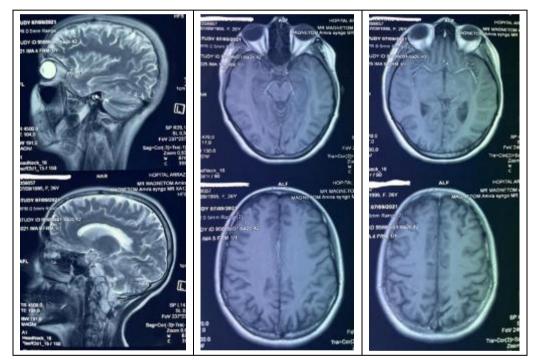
Sequences of MRI brain 03 month after first symptoms for follow up, noted significant improvement with reversibility of the initial lesions
